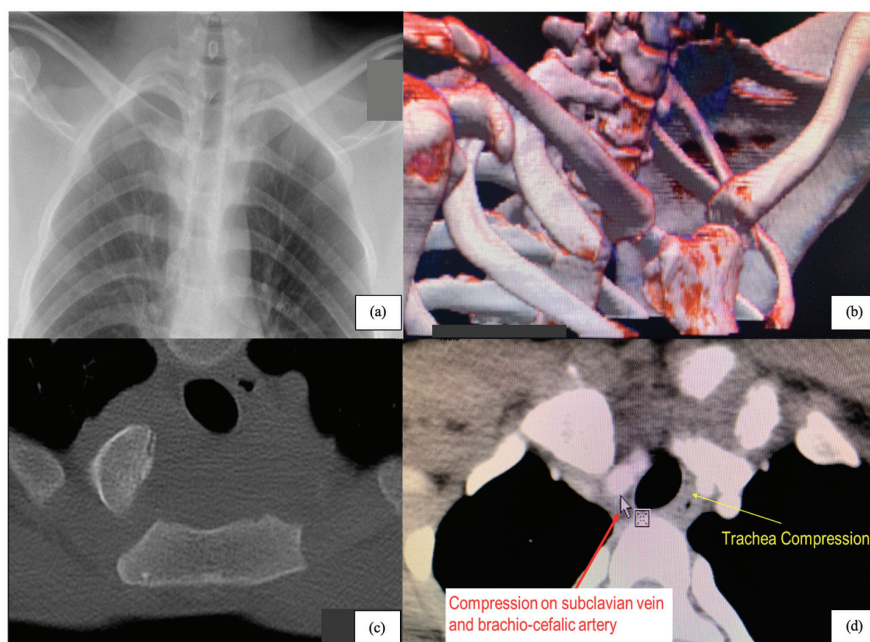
Preoperative evaluation of posterior SCJ dislocation: (a) chest X-ray; (b) 3D reconstruction; (c) axial CT scan bone view; (d) axial CT scan.
